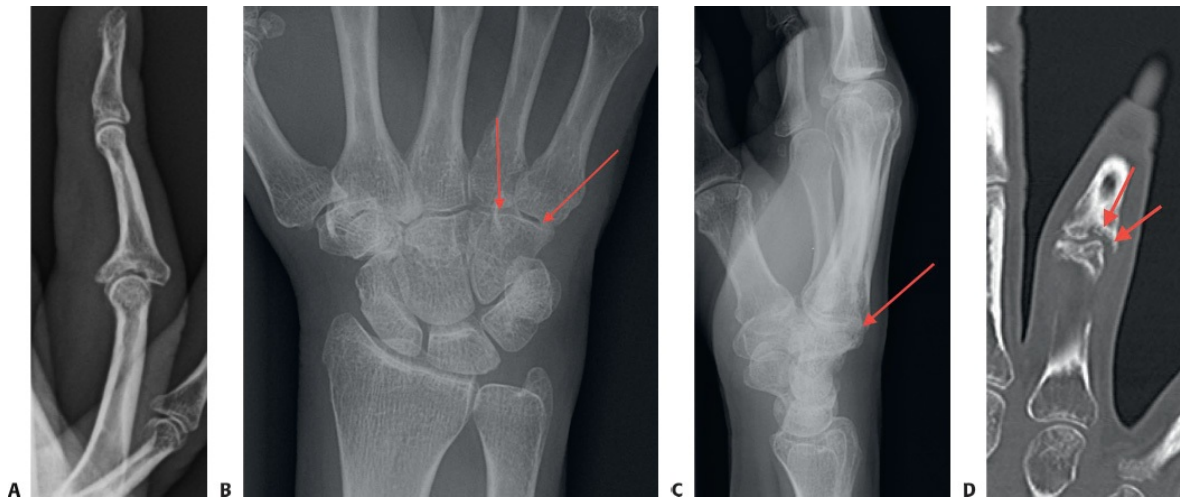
• A. Lateral radiograph demonstrating a patient with a 7-week-old dorsal PIP joint fracture dislocation with involvement of approximately 70% of the articular surface and an intact dorsal phalangeal base. B,C. PA and lateral radiographs demonstrating suitability of the ipsilateral hamate bone for a graft without evidence of fracture or degenerative joint disease. *Arrows* indicate location of harvest site. D. Coronal slice of a CT scan of the same patient revealing an ulnar-sided middle phalangeal defect with impaction causing ulnar deviation of the digit at the PIP joint (*arrows*). Fine slices via CT imaging allow for preoperative planning to determine how to contour the donor graft from the hamate.
